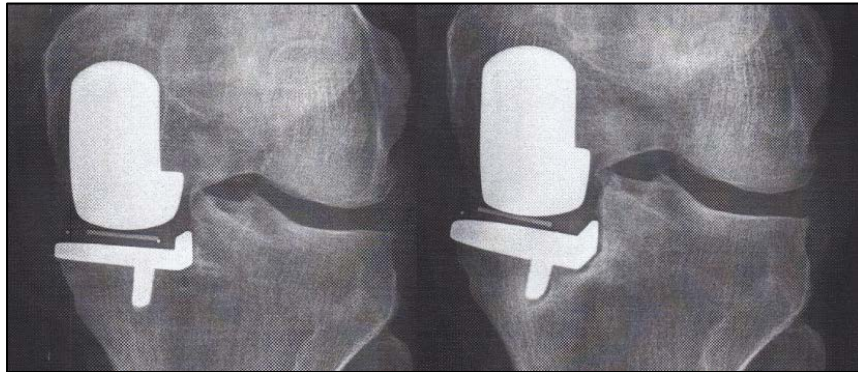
AP radiographs of patient 2
